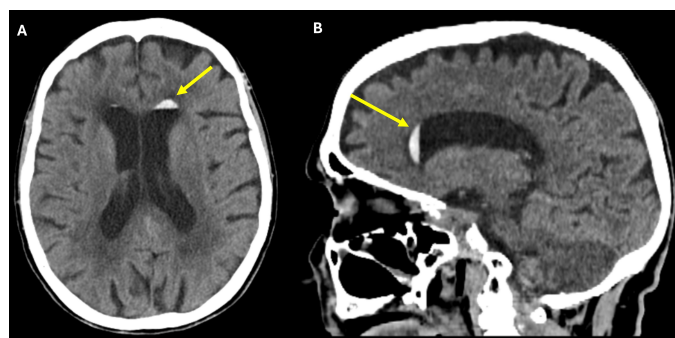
Non-contrast axial (A) and sagittal (B) computed tomography images show a non-dependent, layering hyperdense material in the frontal horn of the left lateral ventricle (yellow arrows). Given that the scan was acquired in the supine position, this appearance is considered atypical for intraventricular hemorrhage.
